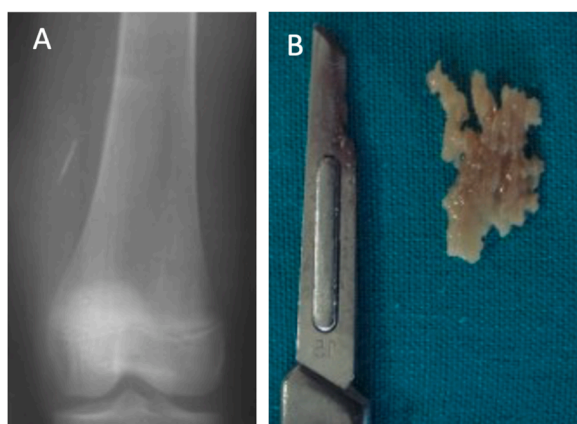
Radiograph of the distal femur with a bone sequestrum in the soft tissue in an 11 years old girl who presented with a torpid medial sinus of 5 years duration. The sequestrum is usually found in a pocket of pus. The bone appears normal, apparently spared by the nearby infection. It is difficult to understand the pathogenesis of such a cases. Sequestrectomy leads to full recovery (B). There is no need of antibiotic therapy once the debridement has been accurate.
